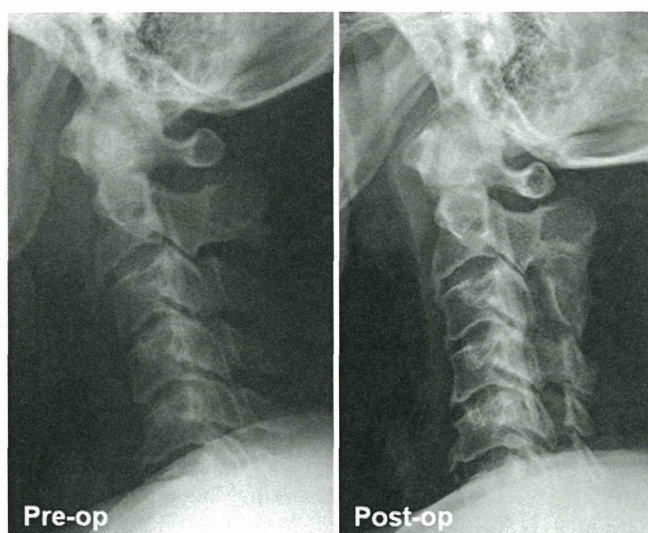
Case 1. Plain lateral radiographs showing the mixed type of OPLL with the continuous type at C2–3 and the segmental type below C-2. However, it was difficult to recognize the segmental type of OPLL below the C-4 level on the preoperative radiograph.
